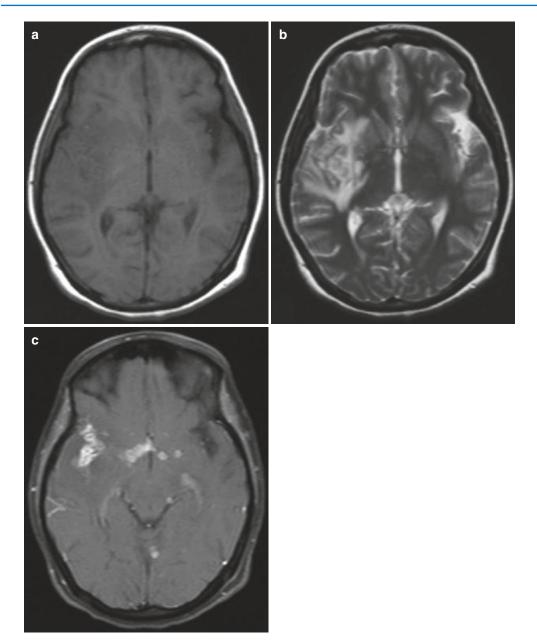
Right temporoparietal oedema is seen as hypointense on T1-weighted image (a) and hyperintense on T2-weighted image (b). There is dense contrast
